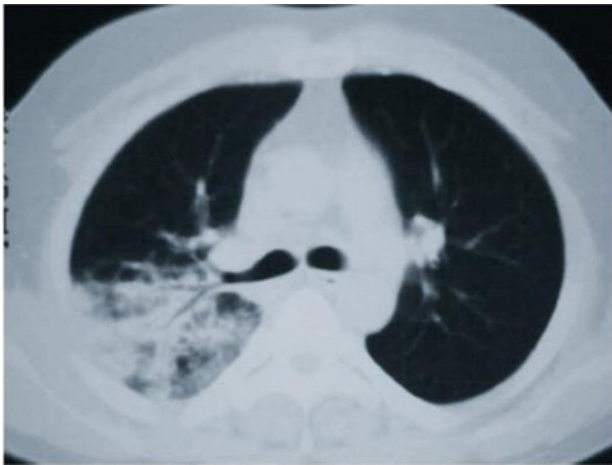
Case 2. CT scan (lung window) shows pulmonary consolidation in right upper lobe
